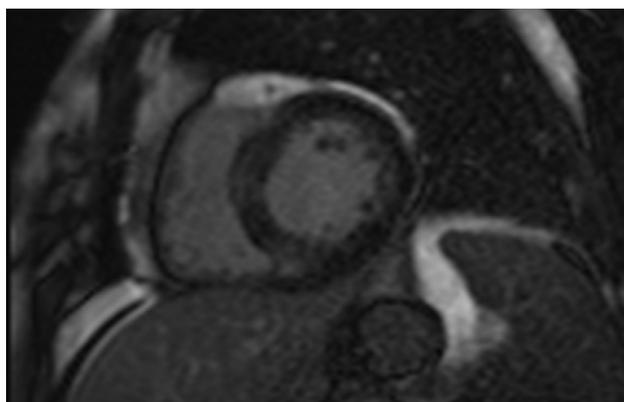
Cardiac magnetic resonance imaging (turboflash sequence) showing areas of late enhancement involving the basal septal wall segments, suggestive of inflammatory process (myocarditis).
